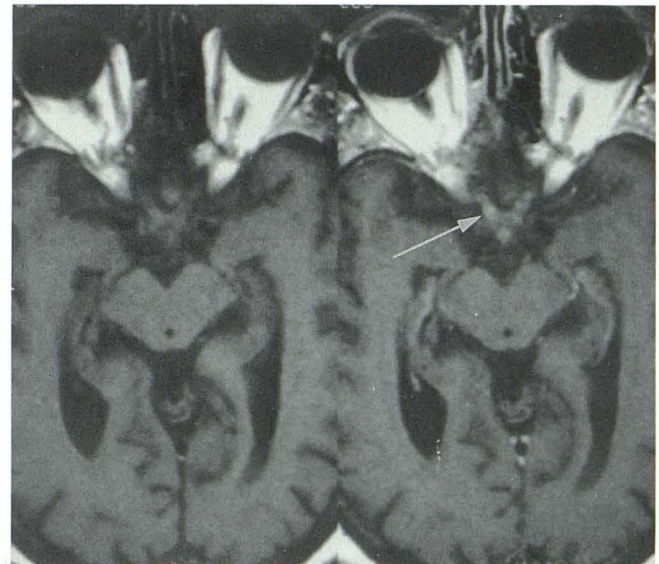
Axial pre- (left) and postcontrast (right) T1-weighted images show discrete focal enhancement of the prechiasmatic right optic nerve (*white arrow*). Irregular enhancement is also noted in the left optic nerve.
